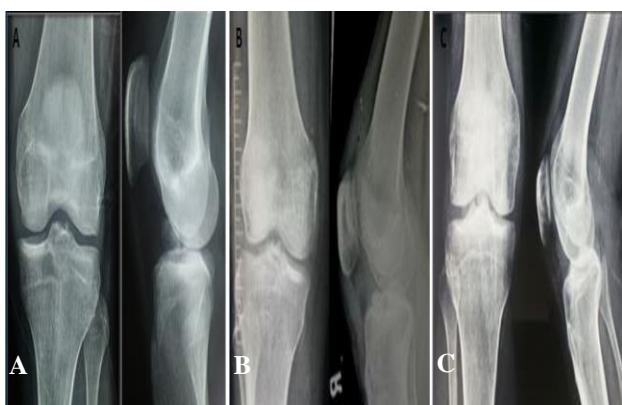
X-ray of a knee with ACL tibial bony avulsion. (A) pre-operative x ray; (B) post-operative x-ray; (C) 2 months post-operative X-ray.
